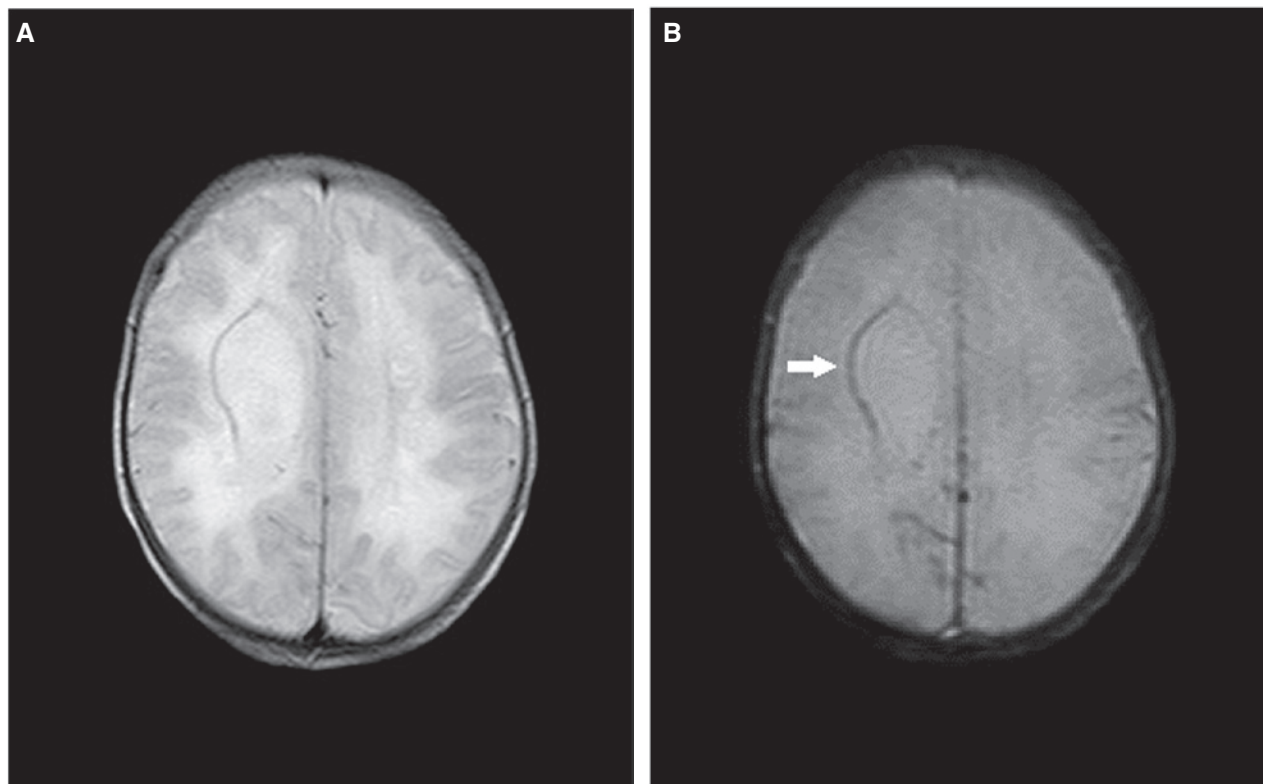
Magnetic resonance imaging at 8 days of age. (A) Focally enlarged right lateral ventricle on T2-WI and (B) linear low signal intensity along the right ventricle on T2*-WI (white arrow).
